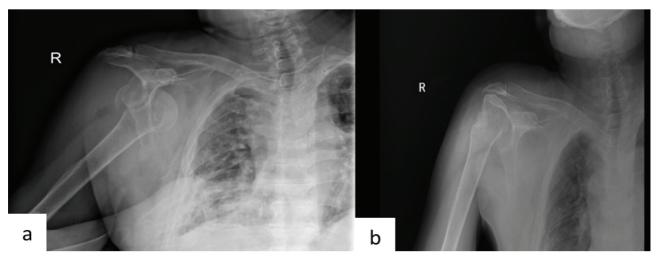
a. Right shoulder radiography posterior dislocation and femoral head fracture, Figure 1. b. Right shoulder radiography after reduction
